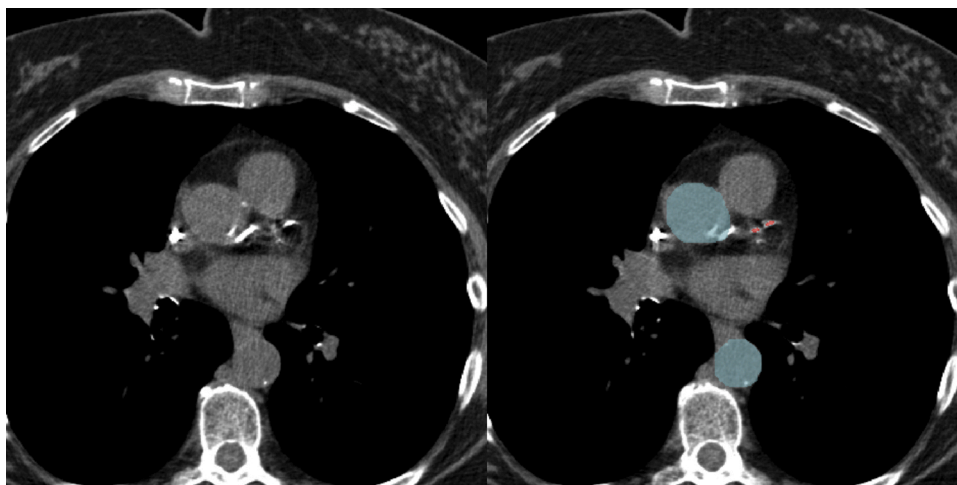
Example of a chest CT image (left) and the same CT image with automated AI based aortic (blue) and coronary calcium (red) segmentation. Using an AI based aortic segmentation step ensures the exclusion of aortic calcium, as is demonstrated in this example.
